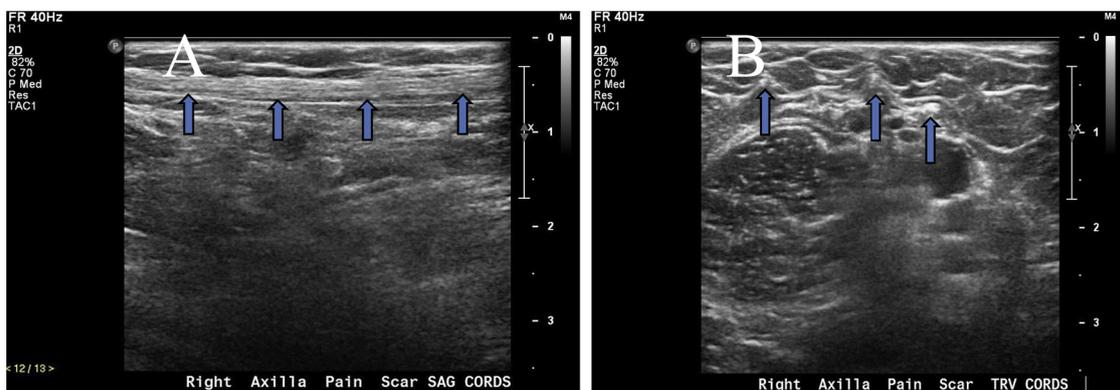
73-year-old woman with history of lumpectomy and axillary node dissection 3 years ago, with a chronic palpable cord in the right axilla. A: sagittal ultrasound of the axillary cord shows an echogenic linear structure corresponding to the palpable cord, B: transverse ultrasound of 3 echogenic cords.
